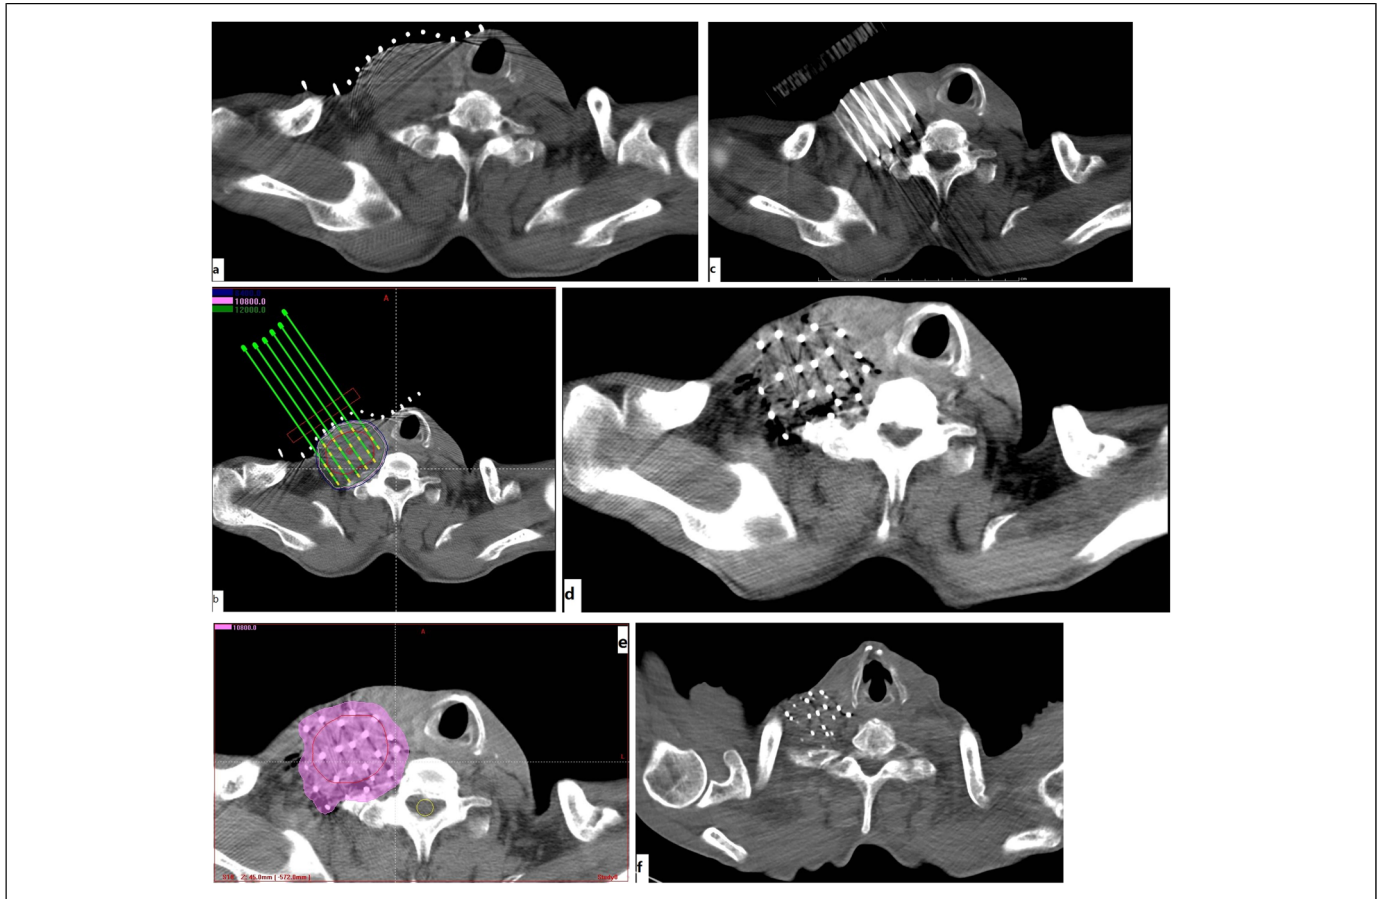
Representative CT scans of a patient during the whole treatment process. (a) Preoperative image. (b) Preoperative plan. (c) Operation process. (d) Postoperative image. (e) Postoperative dosimetry evaluation. (f) Three months after ^{125}I seed implantation.
